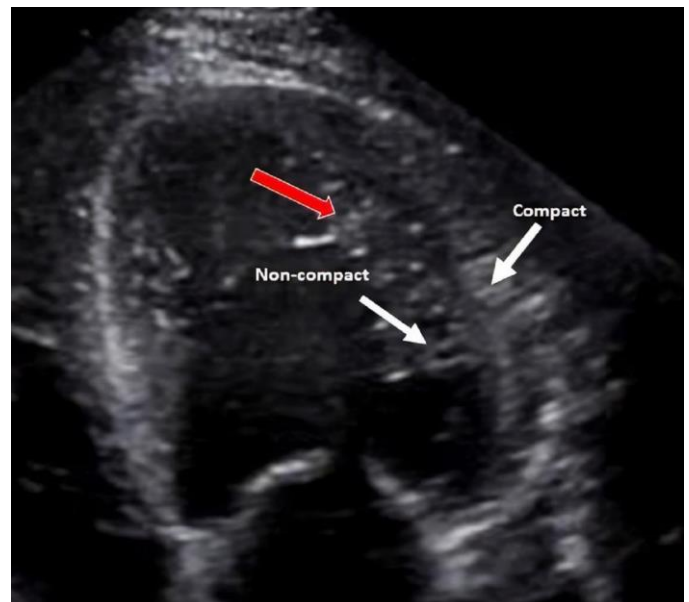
47 year old male presenting with new onset heart failure due to left ventricular non-compaction. Findings: Apical 4 chamber view of left ventricle showing dilated left ventricle with trabeculations noted on the lateral wall (red arrow). Non-compact and compact myocardium displayed on lateral wall.
